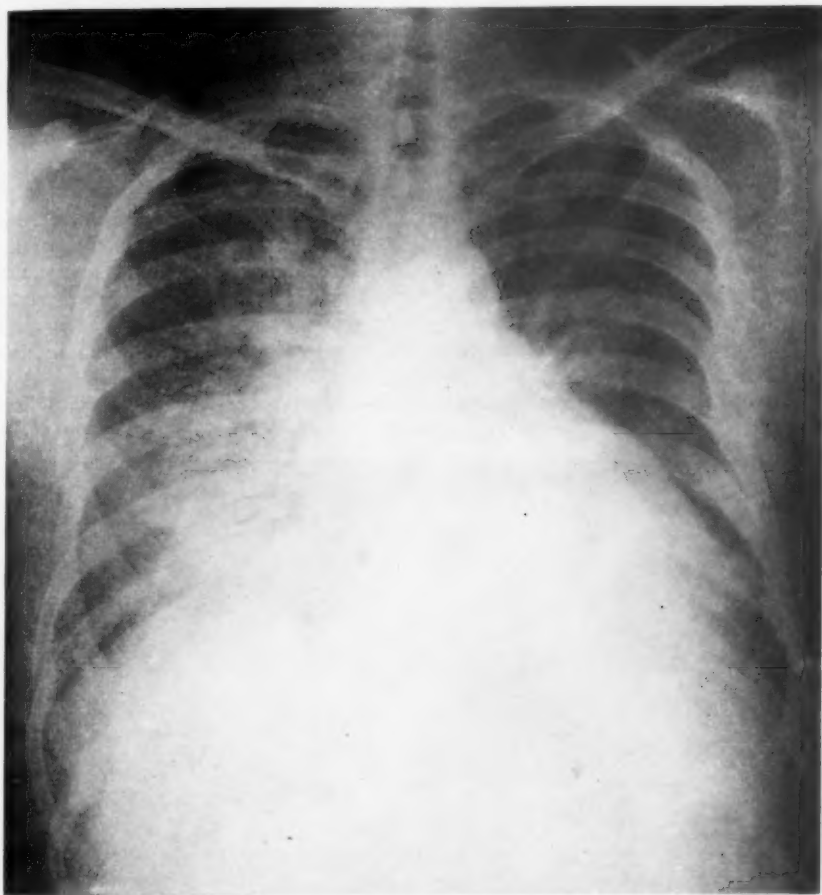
Roentgenological appearance of the chest when the patient showed very pronounced symptoms and signs of left ventricular failure, 3-7-33.
